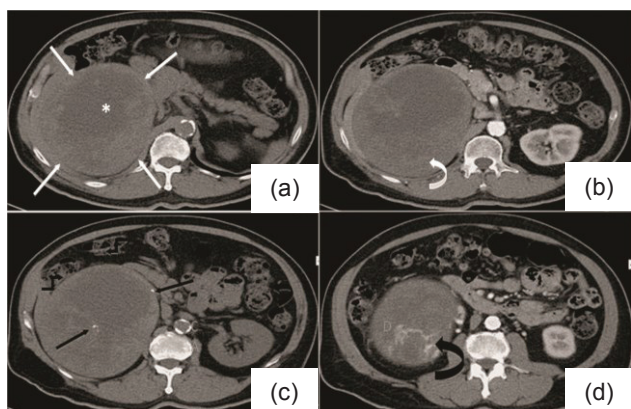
Axial non-contrast (a) and contrast-enhanced (b) CT images showing a large retroperitoneal mass (white arrows) with central hypodensity (*) and peripheral enhancement (curved white arrow); c. Non-contrast axial CT image showing punctate calcifications (black arrows); d. Contrast-enhanced axial CT image showing neovascularization (curved black arrow).
